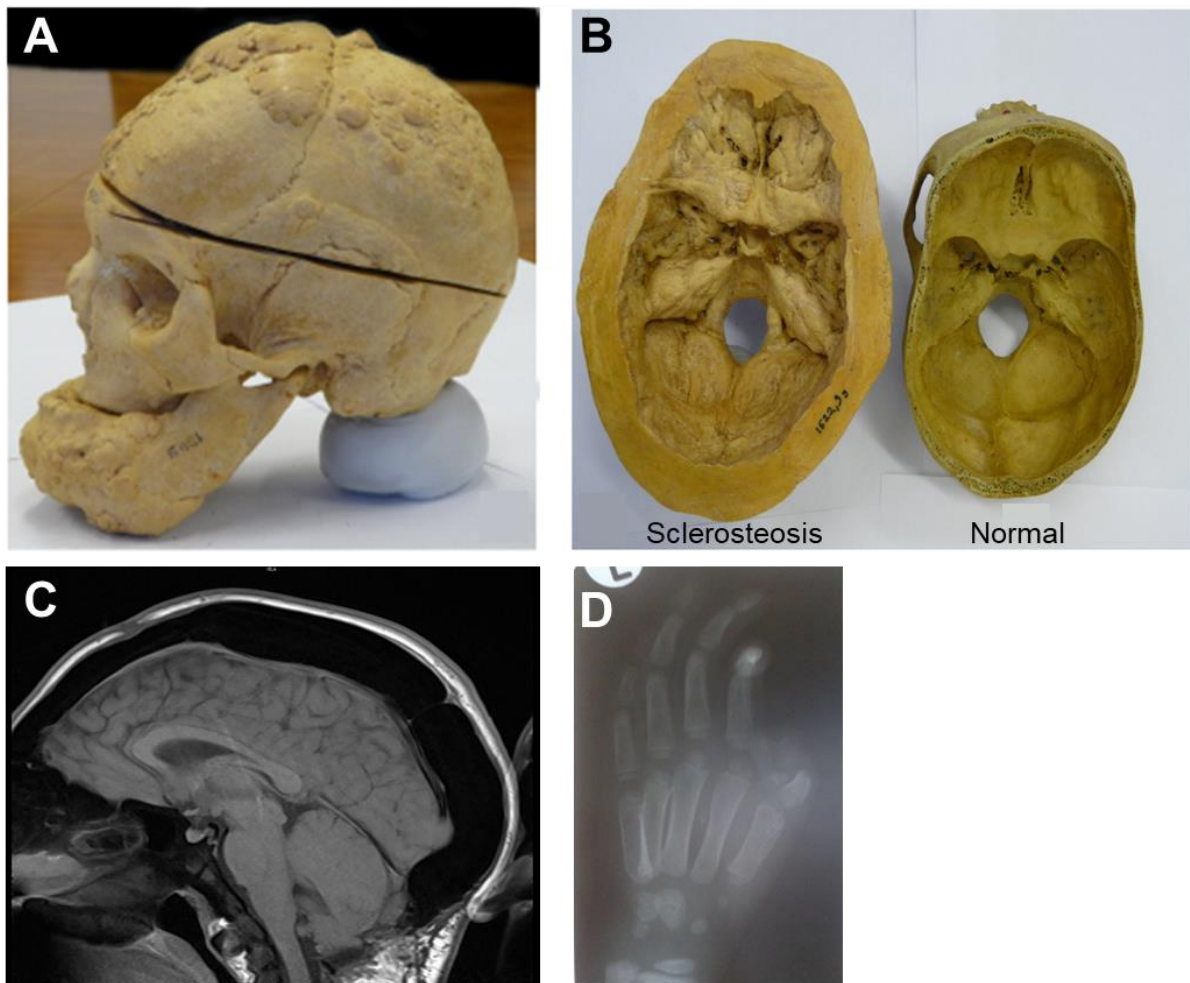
Skull and hand of a sclerosteosis patient. A) and B) Photos of the skull of a patient with sclerosteosis (A) and (B), and an individual without the bone disorder (B). C) MRI of the skull of a sclerosteosis patient, with the black region around the brain representative of excessive bone. D) X-ray image of the hand of a sclerosteosis patient with syndactyly. *From the collection of the University of Pretoria, South Africa (van Lierop et al., 2017).*
